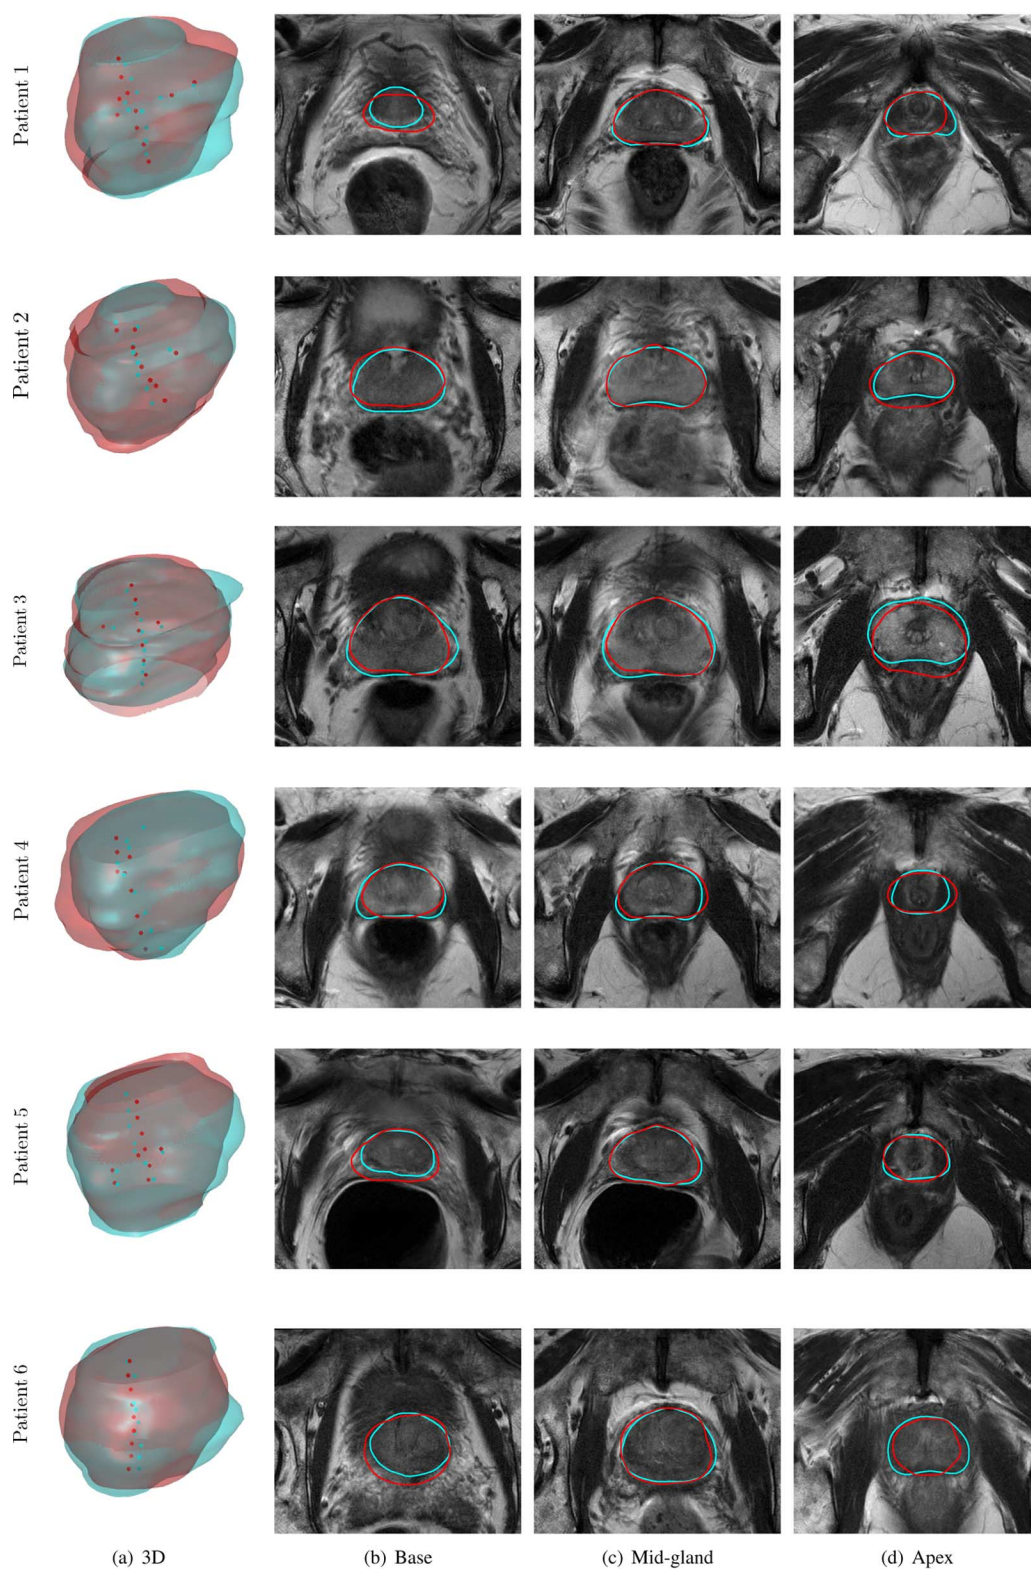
Inhomogeneous registration results. The registered *ex vivo* reference model (red) and a manually segmented model (cyan) of the *in vivo* T2-weighted template image. Spheres in column (a) represent registered and manually marked landmarks. Columns (b)–(d) show cross-sections of the models overlaid on selected T2-weighted slices from the base, mid-gland and apex regions of the prostate.
